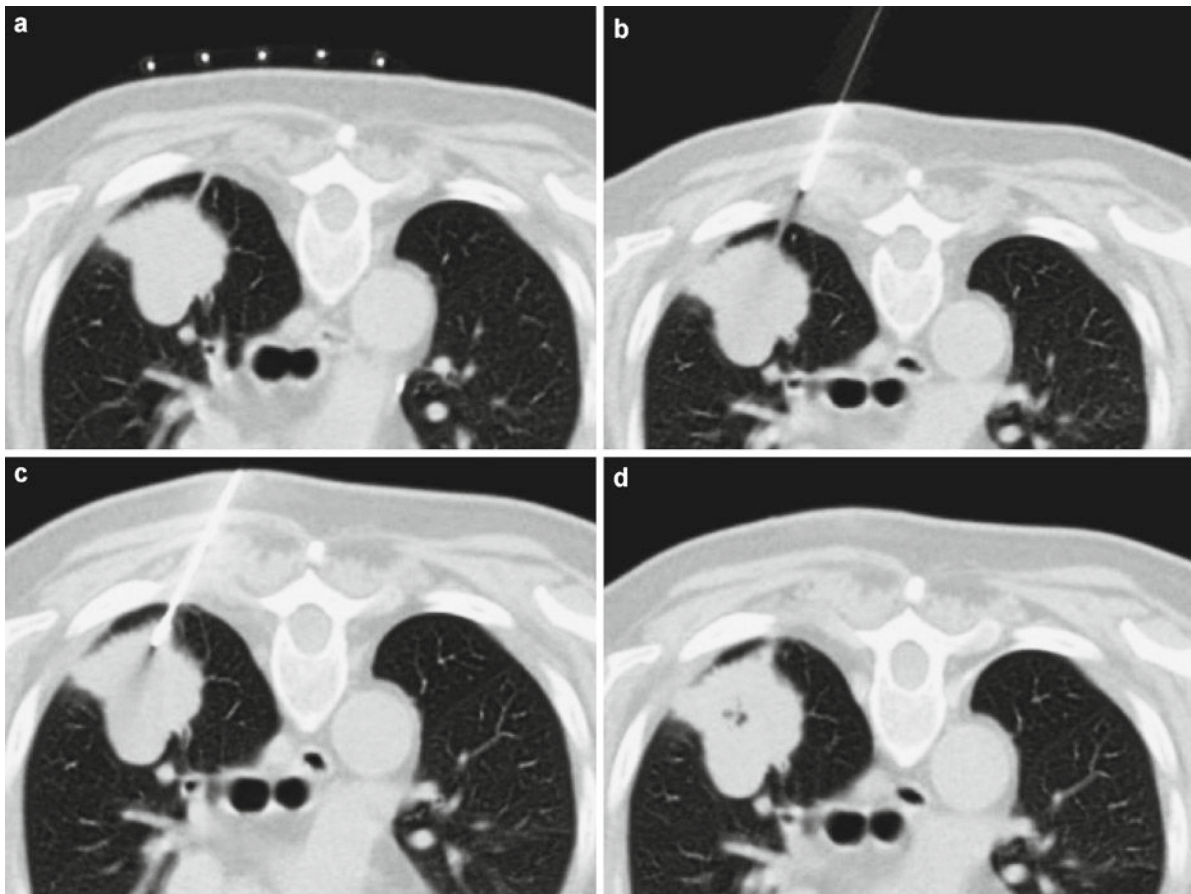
CT-guided lung biopsy in a patient treated for B-cell lymphoma. The planned needle trajectory passed through a pleural tail to avoid the lung parenchyma. The biopsy demonstrated invasive pulmonary aspergillosis
